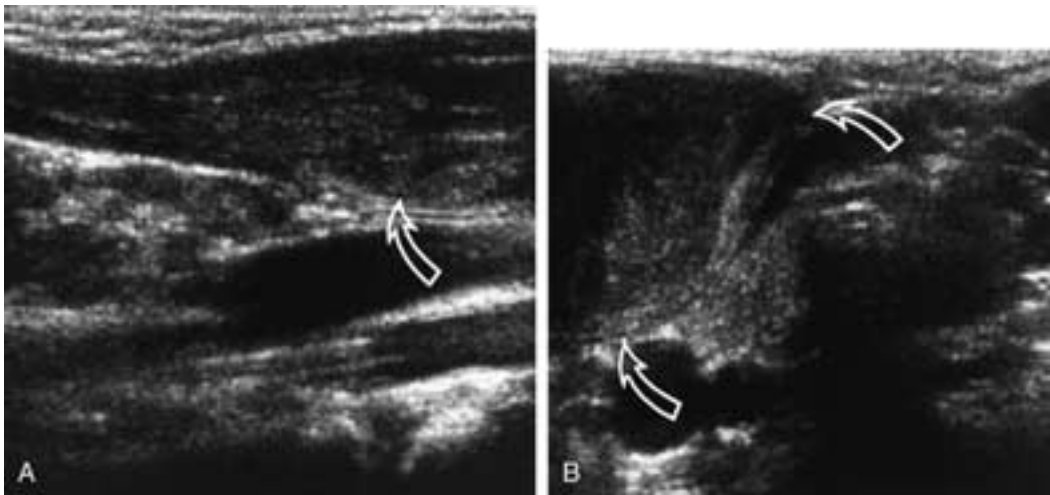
Fibromatosis colli. Oblique coronal ultrasound-image (A) shows that part of the caudal area (curved arrow) of the sternocleidomastoid muscle is enlarged. The axial image (B) shows the abnormality in the sternocleidomastoid muscle (curved arrows), which is slightly inhomogeneous and isoechoic. (Courtesy of Dr. F.J.A. Beek.)
